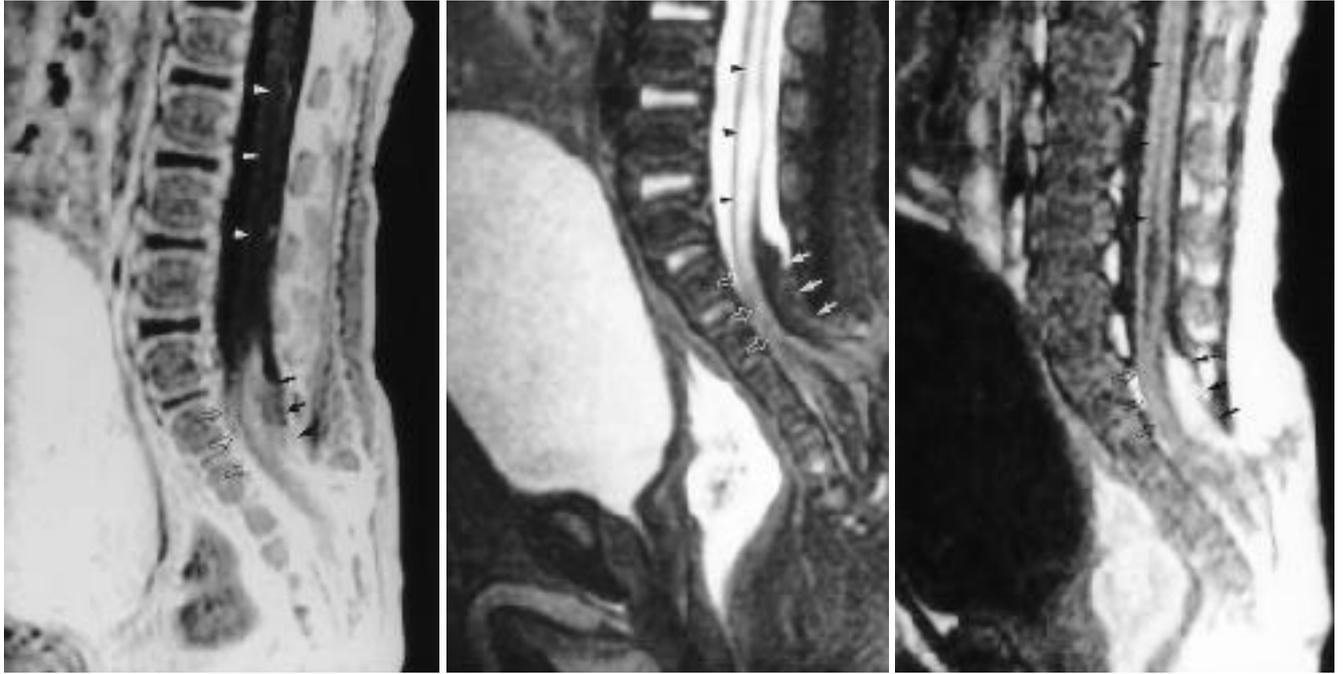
T1-weighted(A) and T2-weighted(B) sagittal images show a high intensity lipoma with tethered cord at L5 level(arrow) and hydroxyringomyelia(arrowheads).
